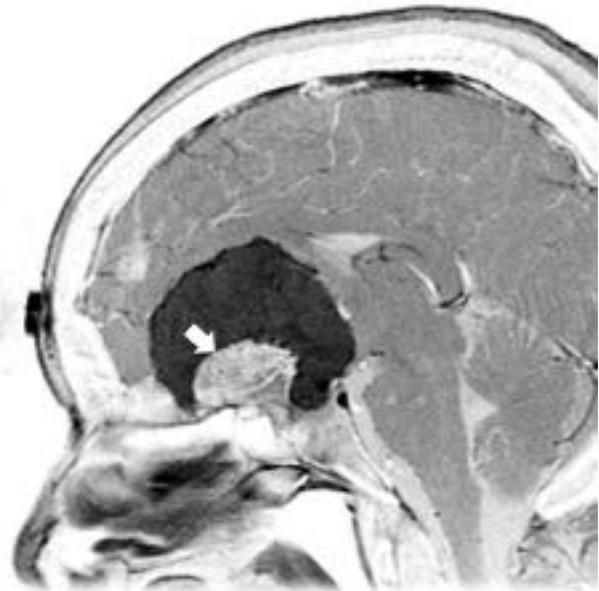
Sagittal postcontrast T1-weighted magnetic resonance imaging reveals a large tumor extending back into the sella turcica. Extensive hyperostosis is present (arrow). Property of the Department of Neurosurgery, The University of Texas M.D. Anderson Cancer Center. Used with permission.
